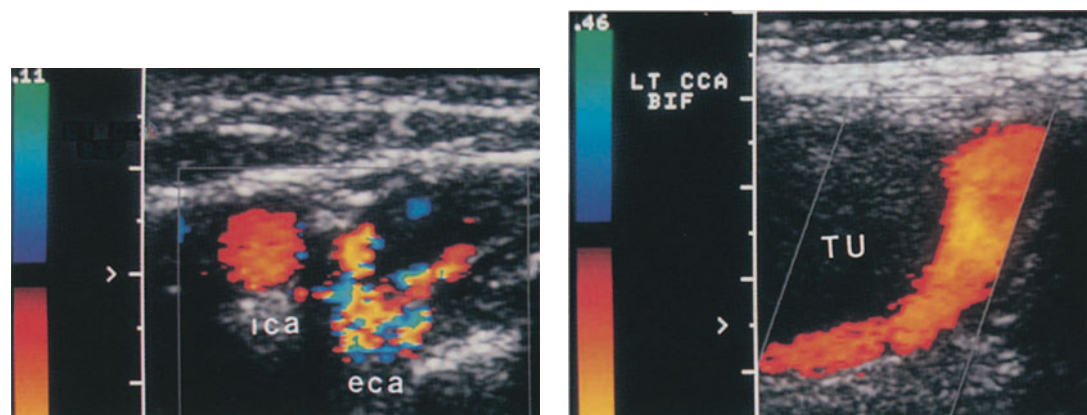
(left) Transverse sonogram at the level of the carotid bifurcation shows tumor feeding vessels originating from the ECA
